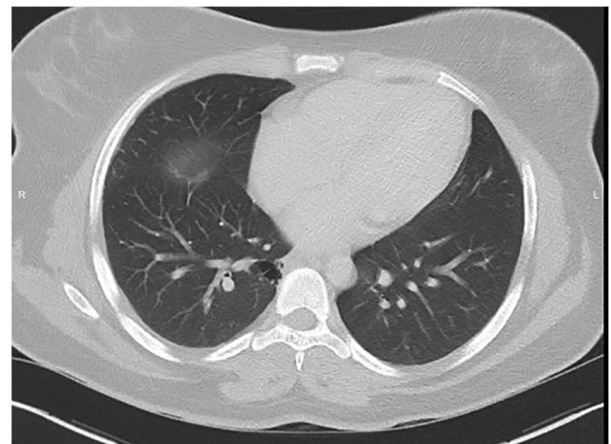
Chest CT scan postpartum: Stability of the lung lesions.
